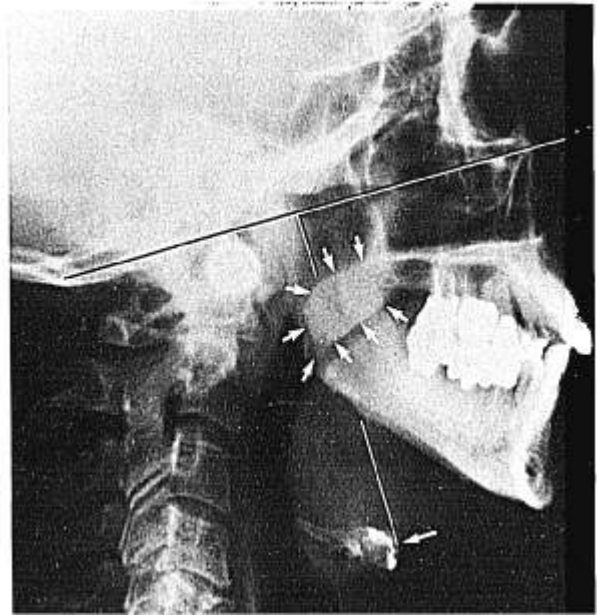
Lateral x-ray of adult male OSA patient. The enlarged soft palate is shown by the area outlined by the small arrows. Note also the more inferiorly located hyoid bone (marked with long arrow) and enlarged distance between the hyoid bone and the Frankfurt horizontal plane.
